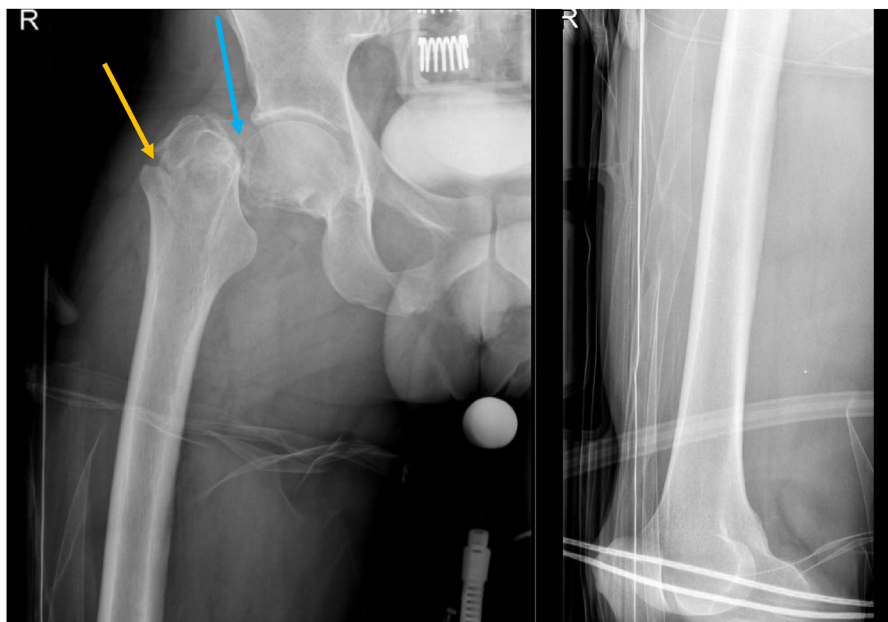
Anteroposterior radiographic view of the patient's right femur. Blue arrows point to subcapital (intracapsular) fracture. Yellow arrows point to trochanteric (extracapsular) fracture.
